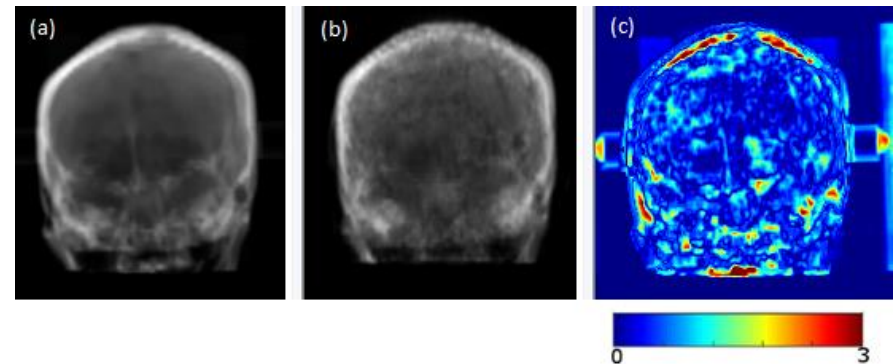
(a) Anterior-Posterior DRRs from CT, (b) from sCT, (c)  $\gamma$  (DTA = 2mm,  $\Delta I = 5\%$ ) map with reference CT-based DRR
